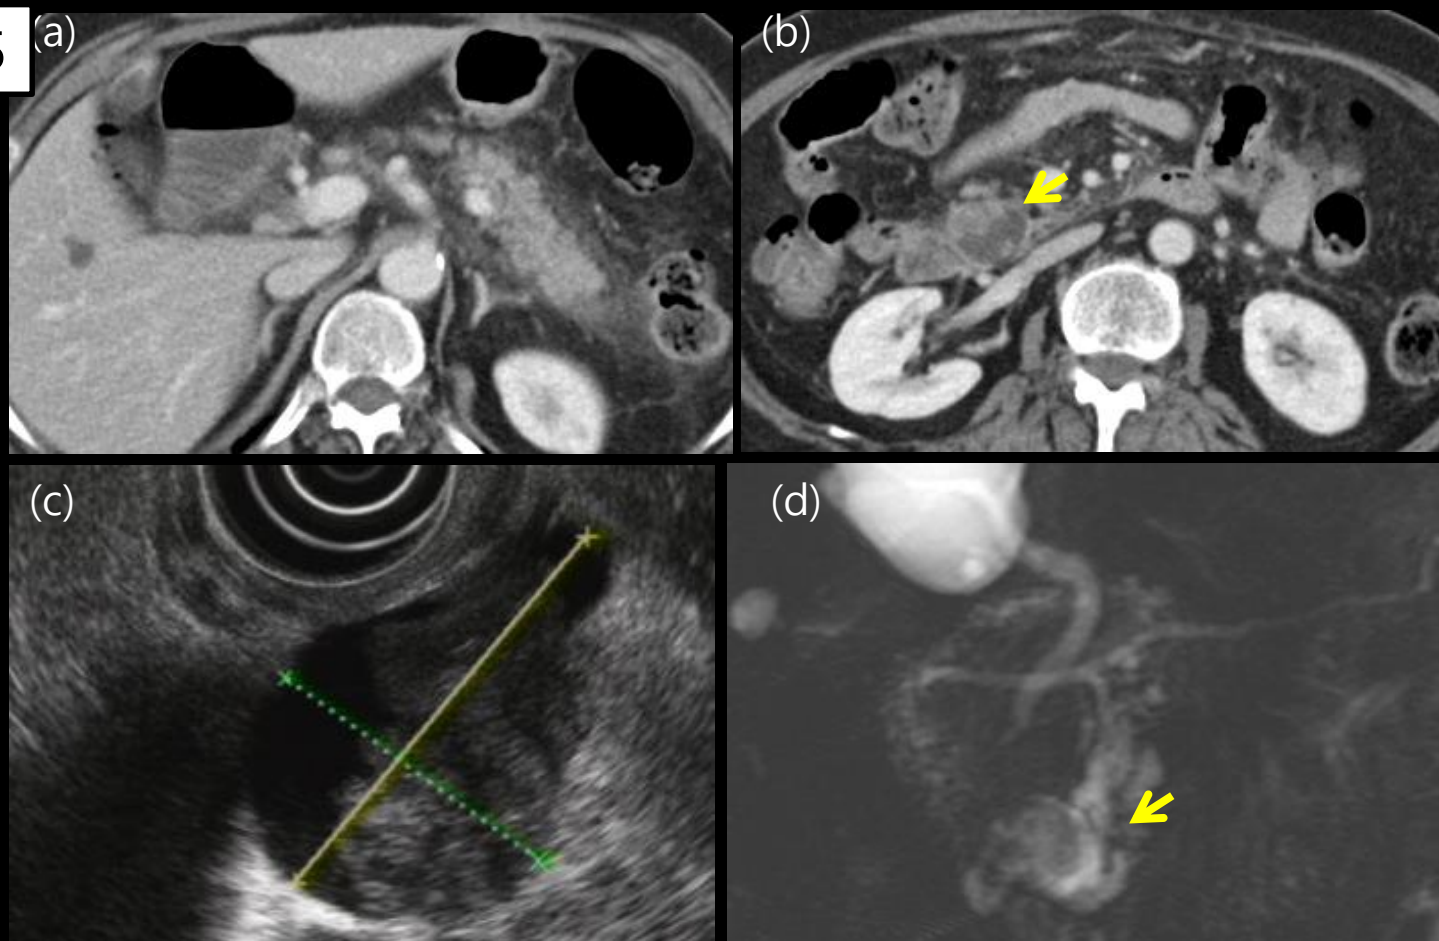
76 years old woman presented with acute pancreatitis by malignant IPMN. (a), (b) Axial contrast material-enhanced abdomen CT images show diffuse pancreatic swelling with with peripancreatic infiltration, fluid collection and cystic lesion with internal eccentric enhancing solid portion (yellow arrow) in between duodenum 2nd, 3rd portion with pancreatic head. (c) Endoscopic ultrasonography depicts anechoic cystic lesion with internal polypoid heterogeneously hypoechoic portion (about 3.4 x 2.4 cm in size) in pancreatic head. (d) In MRCP, cystic lesion (yellow arrow) with internal solid nodular portions has communication with tortuous duct.
